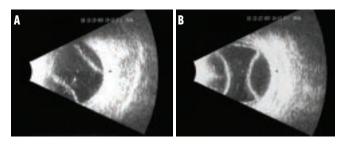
B-scan ultrasound images confirmed the serous nature of the choroidal detachments in the right (A) and left (B) eve.
